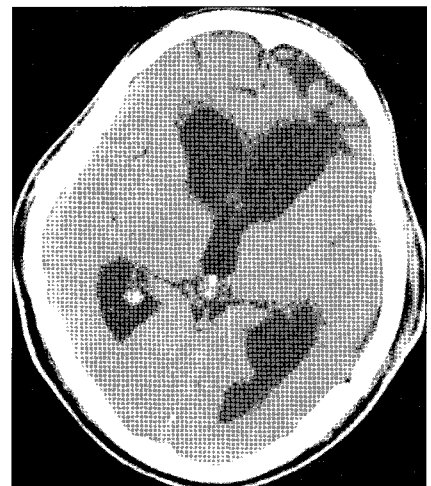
Preoperative initial computed tomography (CT) showing residual cerebromalacia in left frontal lobe and diffuse both lateral ventricles enlargement.
